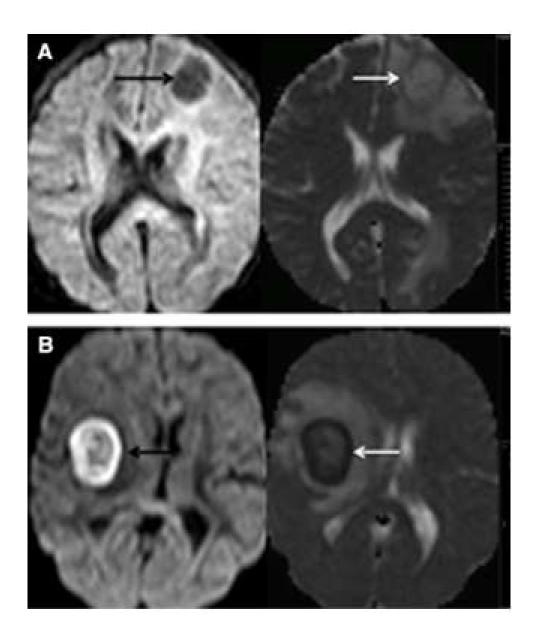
MRI DWI and ADC images of non-caseating and caseating granuloma in Tuberculoma⁵²
